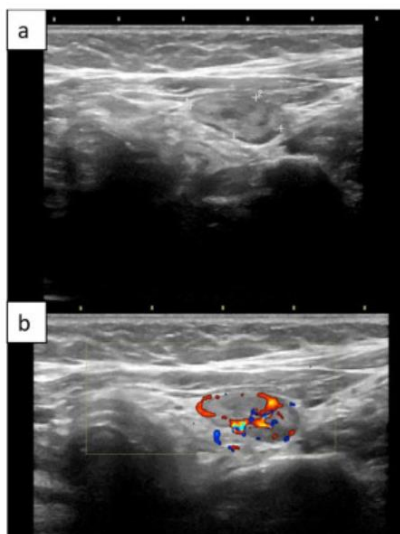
LEFT INFERIOR PARATHYROID ADENOMA OBSERVED BY ULTRASOUND. ADAPTED FROM (9).
